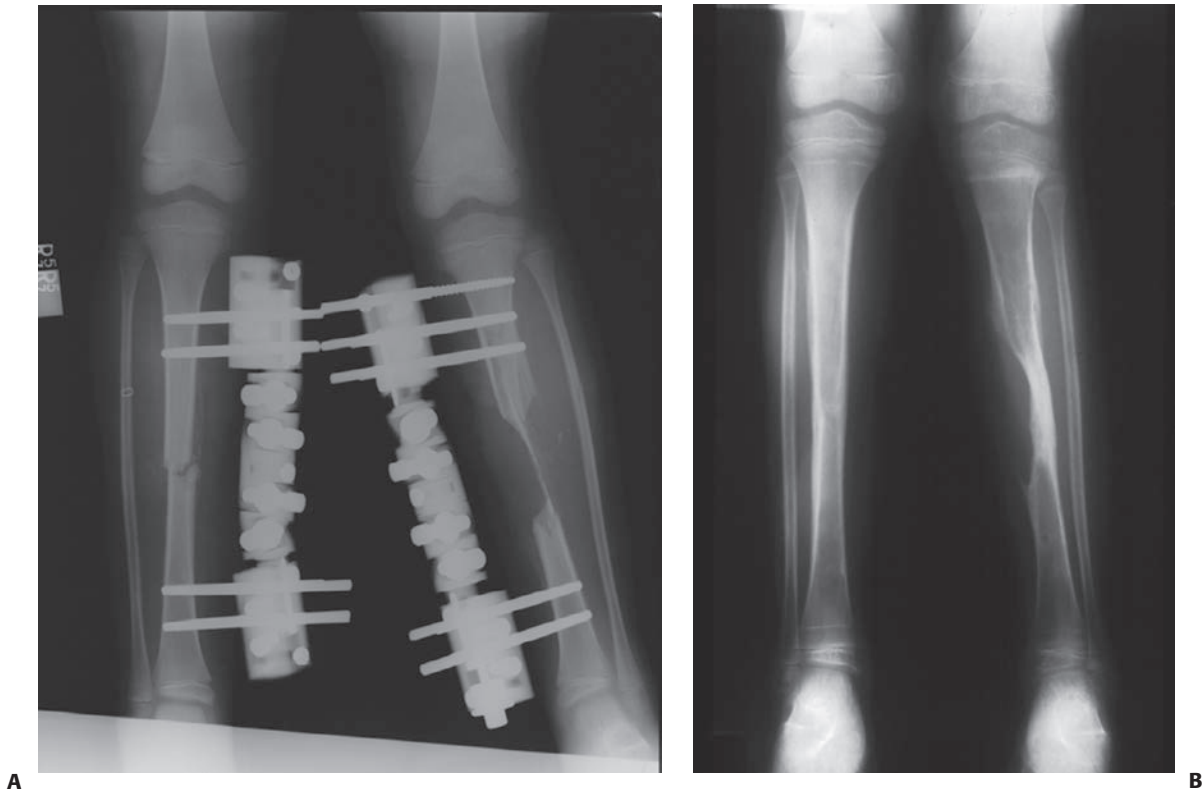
A: AP radiograph of a 6-year-old boy with bilateral open fractures, fixed with external fixators. Note the bone loss on the left, with only a thin piece of cortical bone remaining. However, his periosteum was preserved. B: Result at 1 year, with healing and hypertrophy of the cortical bone, without bone grafting.
